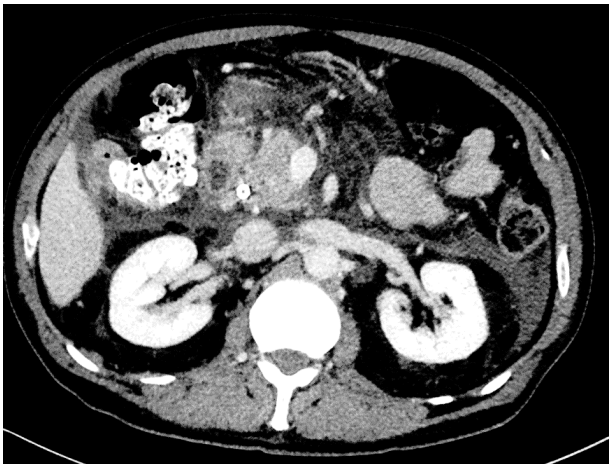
CT scan of patient with PEP: edema of pancreatic head, metal stent in ductus choledochus (common bile duct).
